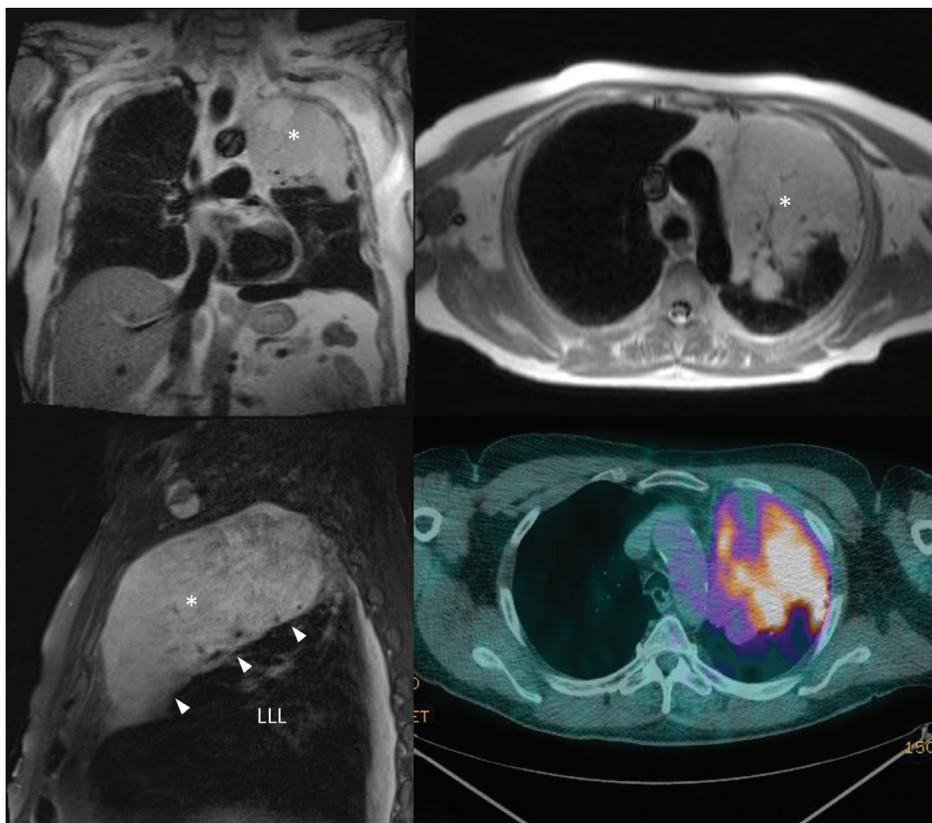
Coronal (*top left*) and transaxial (*top right*) HASTE MR images of the chest demonstrating a large mass (*) near completely occupying the entirety of the left upper lobe. Sagittal T2 weighted fast-spin echo MR image (*bottom left*) shows a diffusely high intensity signal mass (*) throughout the left upper lobe. Note the left major fissure (*arrowheads*) delineating the boundary with the LLL. Whole body positron emission tomography-computed tomography image (*bottom right*) obtained 1 day before the thoracic MRI demonstrates the high and heterogeneous FDG avidity of this neoplasm. HASTE, Half Fourier Acquisition Single Shot Turbo Spin Echo; LLL, left lower lobe; MR, magnetic resonance.
